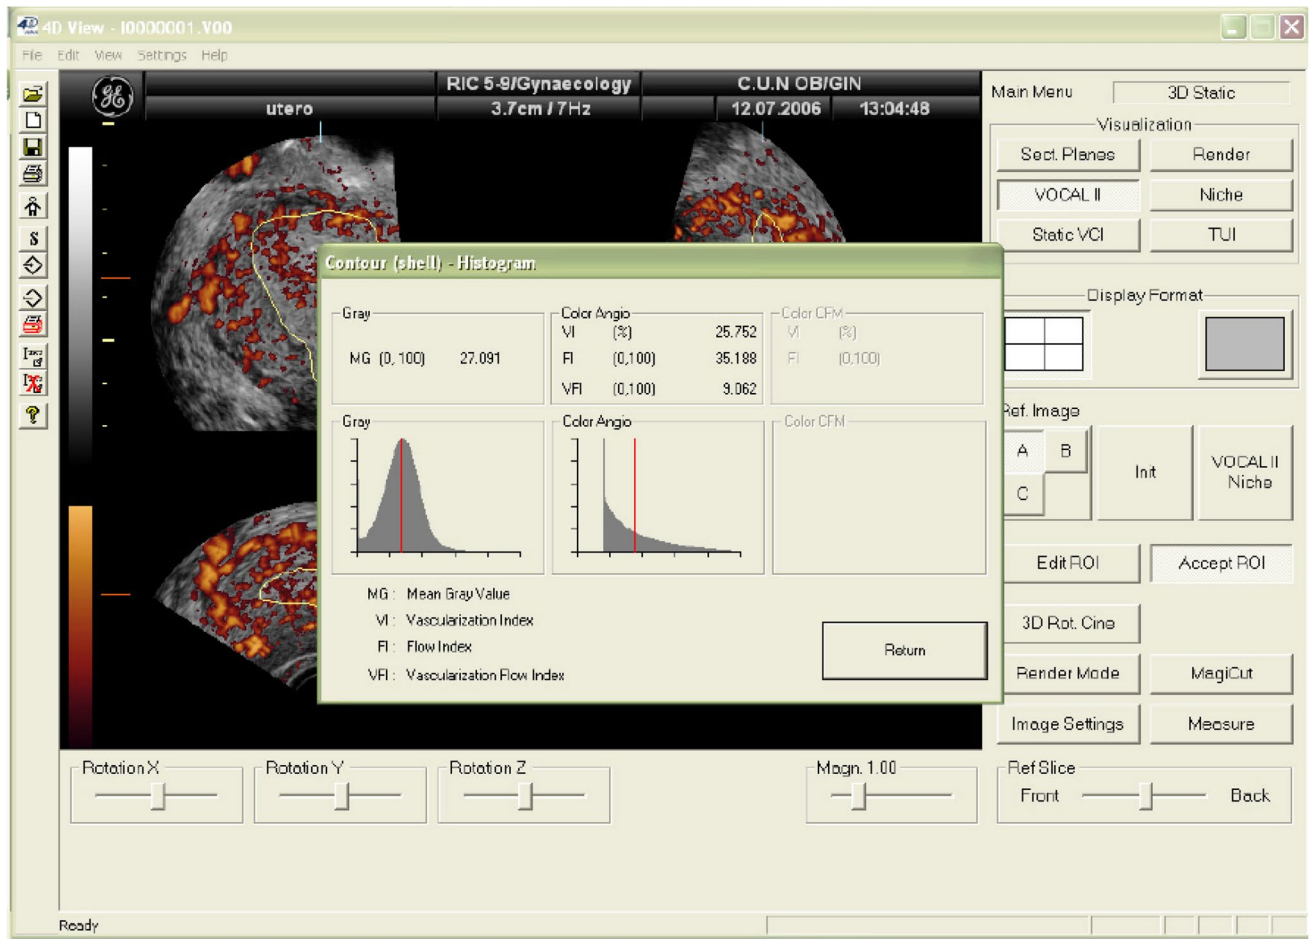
5D-power Doppler indexes for assessing endometrial vascularization by means of the three-dimensional ultrasound [12]
